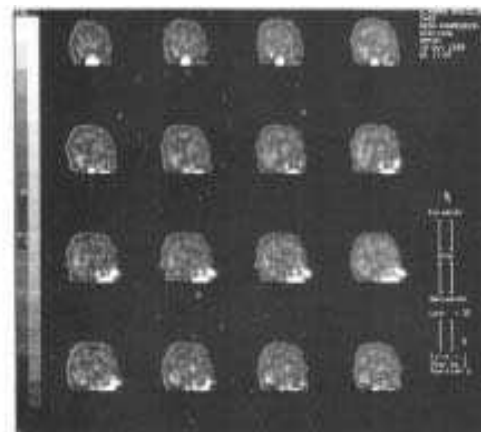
Patient no. (12): Follow up after 6 months, SPECT scan showed perfusion defects in right frontal and left occipital cortex. Rest of the brain fairly perfused (sagittal view).
